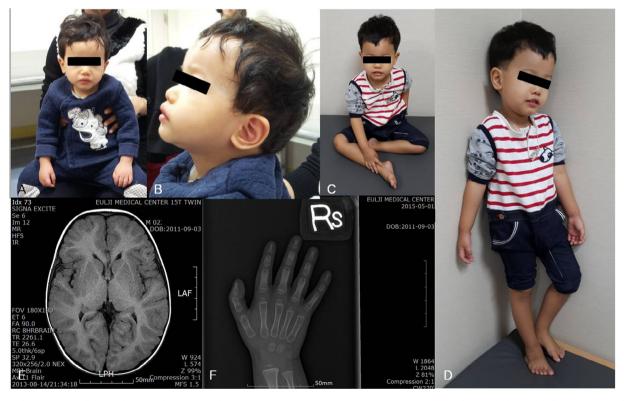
Photographs of the patient aged 2 years and 6 months (A and B) and 4 years (C and D). (E) Microcephaly and dolichocephaly, without definite brain anomalies, are apparent on 1.5 T magnetic resonance imaging. (F) The radiographic bone age of the patient's left wrist at 4 years corresponds to that of a child of 2 years and 8 months according to the Greulich and Pyle standard. And it also shows clinodactyly of the fifth finger.
